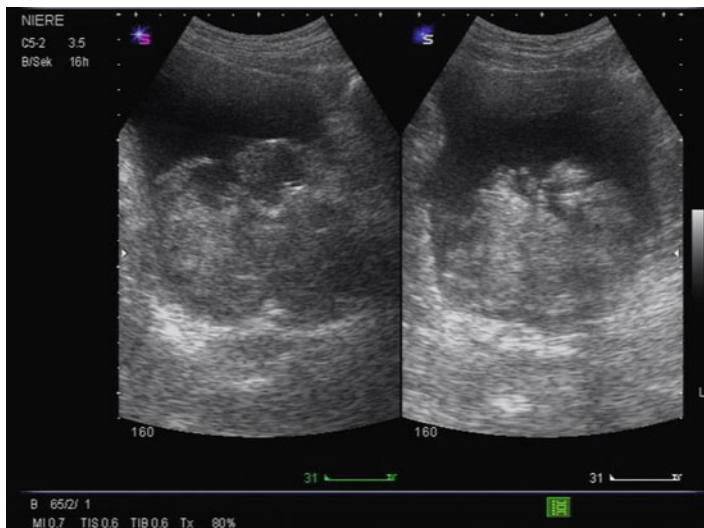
Clot retention – diagnosis by ultrasound examination
